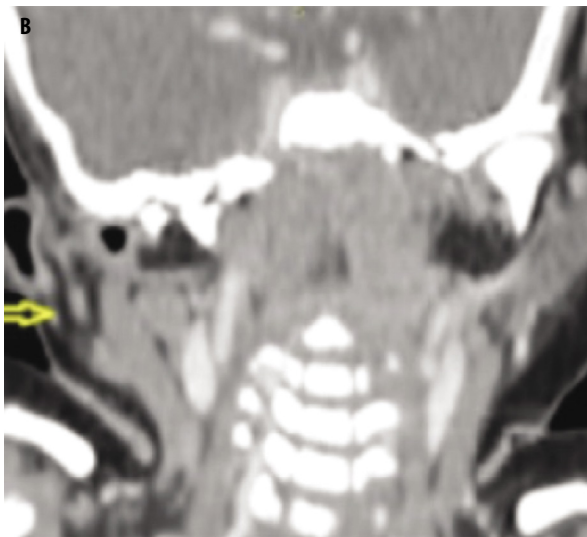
B. Coronal contrast-enhanced computed tomography demonstrated a fistulous tract extending inferiorly to the right angle of the mandible, with heterogeneous collection in the subcutaneous plane (yellow arrow)
